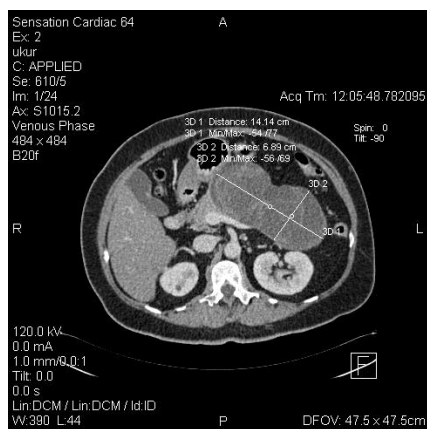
CT scan with large cysts in pancreatic body and tail with multiple septae
